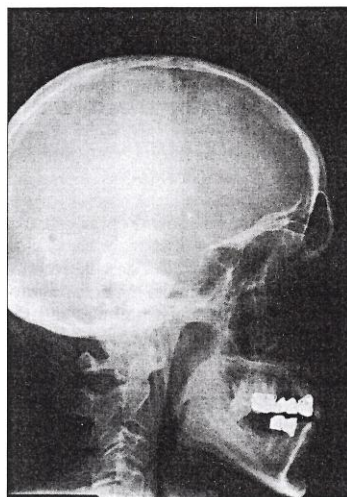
Lateral cephalometric radiograph of the father. Short anterior cranial base, short maxilla, normal facial height.
